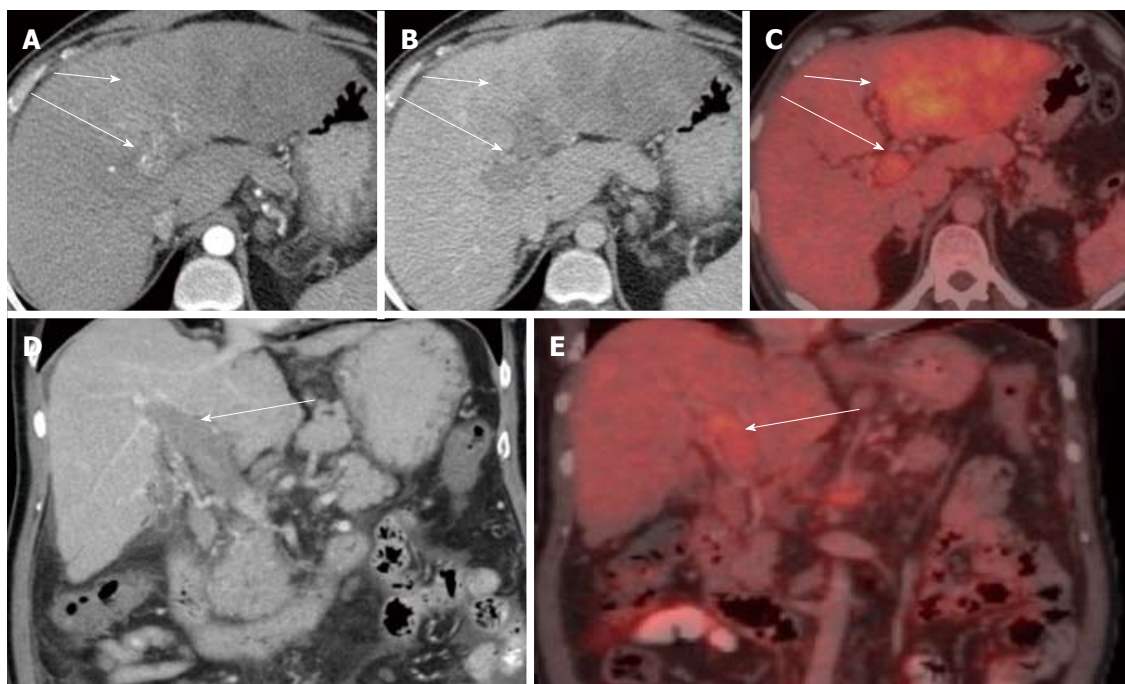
Vascular invasion. A large ill-defined left lobe mass with no significant arterial enhancement (A) and washout in the portal venous phase (B). An FDG-PET CT was done which revealed uptake in the left lobe mass (C) consistent with a hypermetabolic tumour. Arterial enhancement is noted within the distended thrombus filled portal veins in (A) with subsequent washout (B) suggestive of tumour thrombus. The tumour thrombus also demonstrates increased uptake on FDG-PET (C). Coronal images better depict the distended thrombus filled portal vein (D) with increased uptake on PET/CT (E) (short arrow: tumour; long arrow: tumour thrombus). PET: Positron emission tomography; CT: Computed tomography; FDG: Fluoro-2-deoxy-D-glucose.
